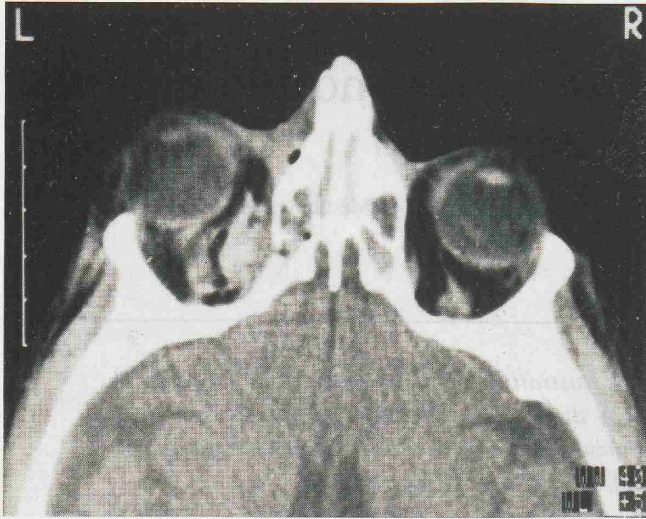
CT scan of the patient shows haematoma in the medial portion of the orbit.
